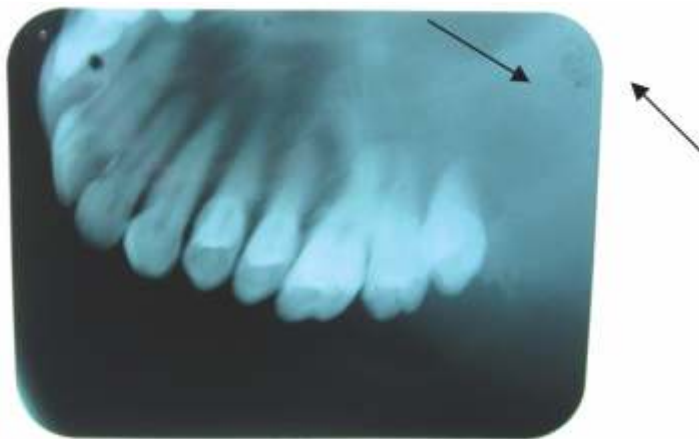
Occlusal radiograph shows altered trabecular pattern.
